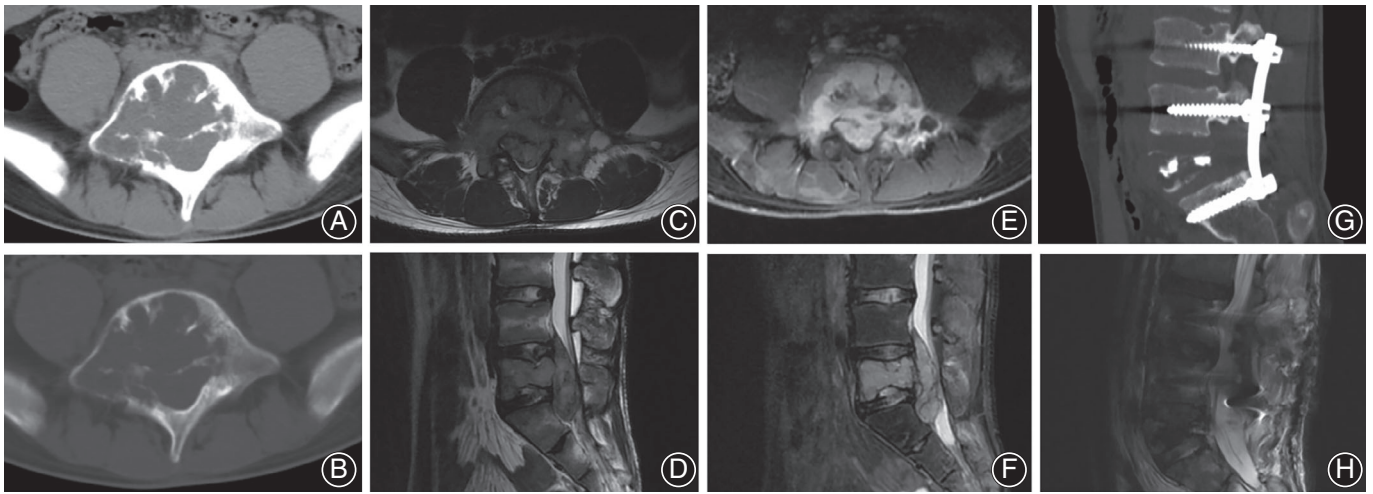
A 16-year-old man with giant cell tumor of L₅. (A, B) Axial CT images, bony septa are seen at the border of the tumor. (C, D) T2 weighted MRI showed an expansile mass with heterogeneous low-to-iso signal intensity with cystic areas. (E, F) Enhanced MRI shows obvious lesion enhancement. (G, H) Managed with intralesional spondylectomy.
